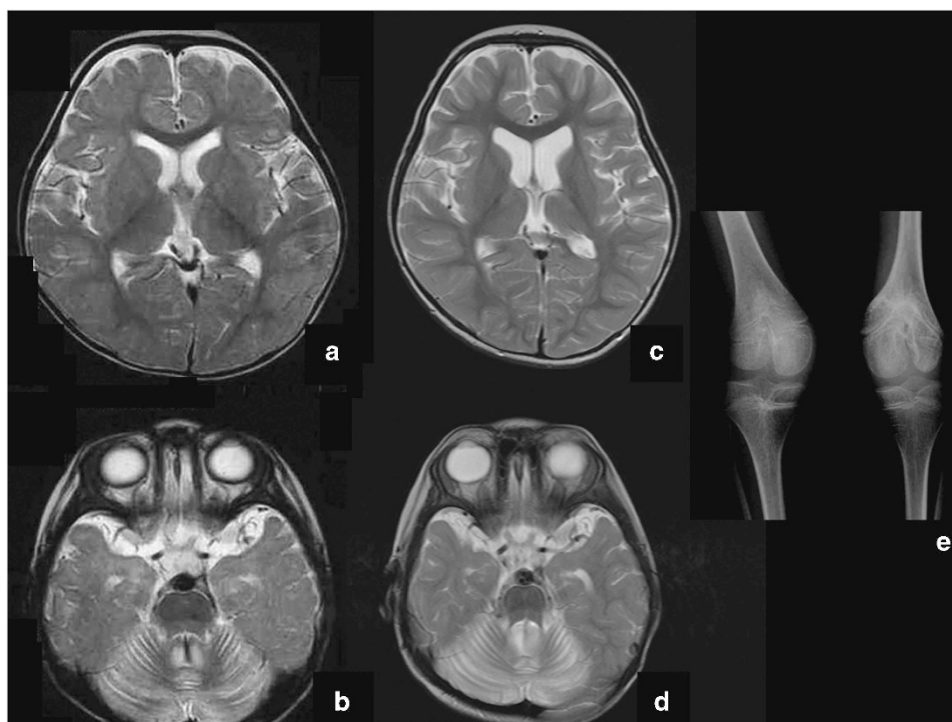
(a–d) Brain MRI of the case. (a, b) Hyperintensity of the cerebellar cortex on T2-weighted images was visible at 10 months. (c, d) Progressive atrophy of cerebellar cortex and caudate and hyperintensity of the cerebellar cortex on T2-weighted images was seen at 5 years. (e) Skeletal radiography of the patient's knees at 12 years. Epiphyseal dysplasia in both femoral metaphysis was seen.
